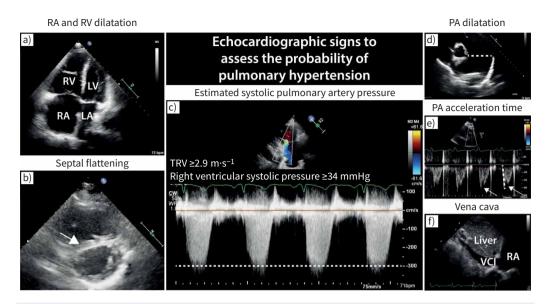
Echocardiographic signs to assess the probability of pulmonary hypertension (PH). a) Right atrial (RA) and right ventricular (RV) dilatation. In addition, the left atrium (LA) and left ventricle (LV) exhibit smaller dimensions due to under filling. b) Flattening of the interventricular septum (white arrow). c) The maximum velocity of the tricuspid regurgitation jet (TRV) assessed by continuous wave Doppler to estimate systolic pulmonary artery pressure. d) Dilatation of the pulmonary artery (PA). e) Shortening of the Doppler PA acceleration time and a mid-systolic PA notch (arrows). f) Dimensions of the vena cava inferior (VCI) to estimate right atrial pressure. D'ALTO *et al.* [13] showed that a TRV $\ge 2.9 \text{ m}\cdot\text{s}^{-1}$ has the strongest diagnostic value to predict the presence of PH according to the new haemodynamic definition of mean pulmonary artery pressure >20 mmHg (sensitivity 83%, specificity 91%, positive predictive value of 99% and accuracy 83%).
